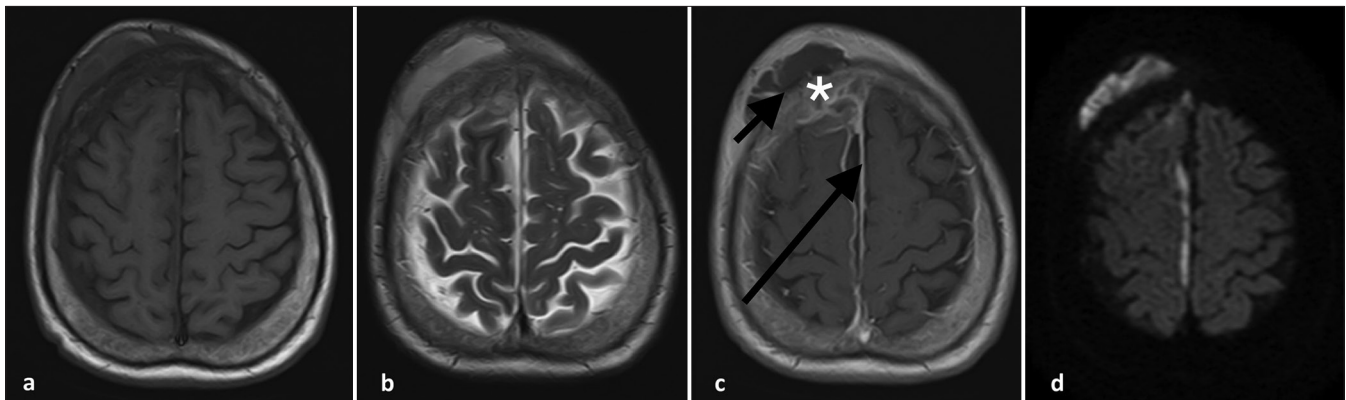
Contrast-enhanced magnetic resonance imaging study. (a) Axial T1-weighted image, (b) T2-weighted image, (c) Gadolinium-enhanced T1-weighted image, (d) diffusion-weighted image. Figure 2c depicted a typical appearance of a subgaleal abscess (short arrow) and a subdural abscess (long arrow), showing a rim-enhancing, cystic lesion with restricted diffusion. Diffuse dural enhancement is shown to be more prominent in the right cerebral convexity. The right frontal bone exhibits bone marrow edema and enhancement, suggestive of acute osteomyelitis (asterisk).
